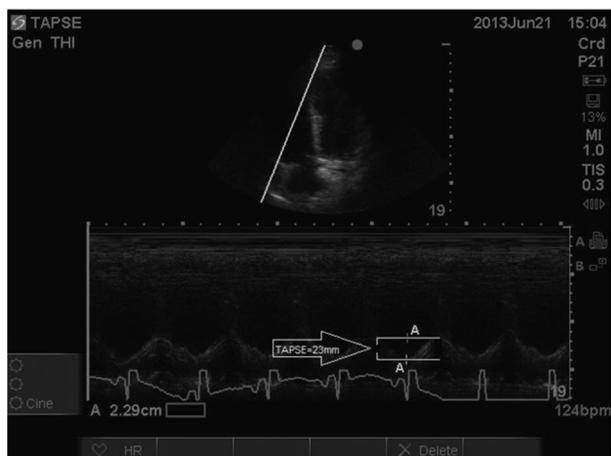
Apical four-chamber view with M-mode cursor placed through the lateral annulus of the tricuspid valve. Normal TAPSE is >17 mm. In this example, the TAPSE is normal at 22.9 mm. HR = heart rate; TAPSE = tricuspid annular plane systolic excursion.
